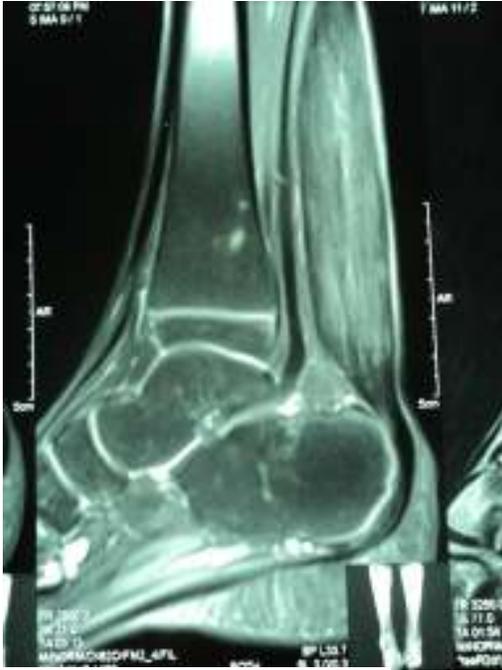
MRI of Achilles tendon
